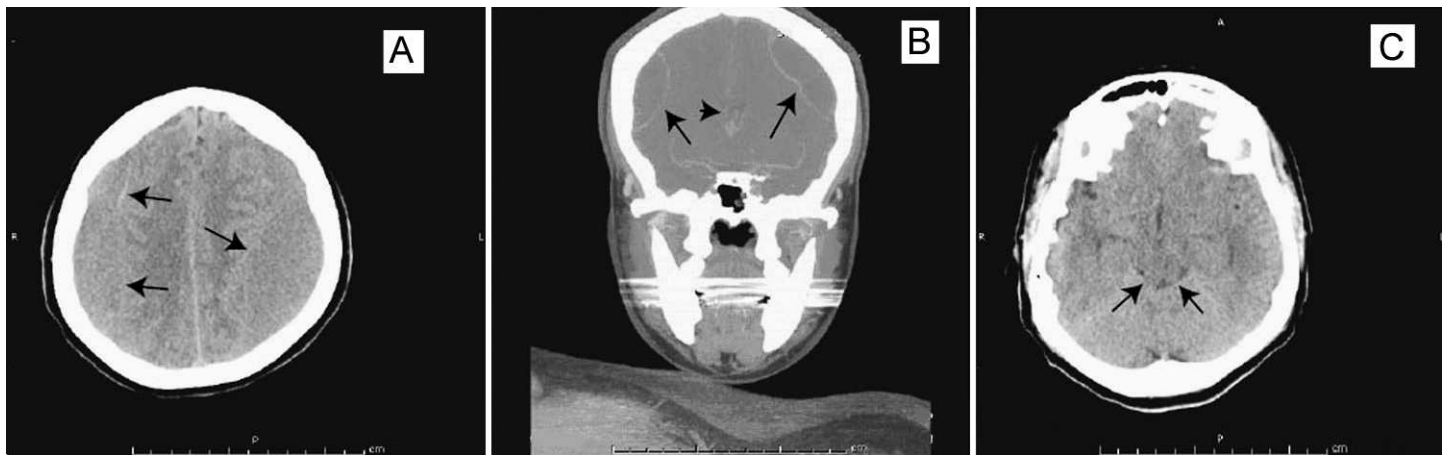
Computed tomography (CT) of the head showing bilateral subacute hematomas at the convexity of both hemispheres with ventricle compression. A, Transverse CT of the head with bilateral subdural hematoma (arrows). B, Axial CT of the head demonstrating bilateral subdural hematomas (big arrows) and compression of the ventricle (arrowhead). C, The diminishing of the basal cisterns next to the brain stem indicates the increased intracranial pressure and downward displacement of the brain caudally (arrows).
